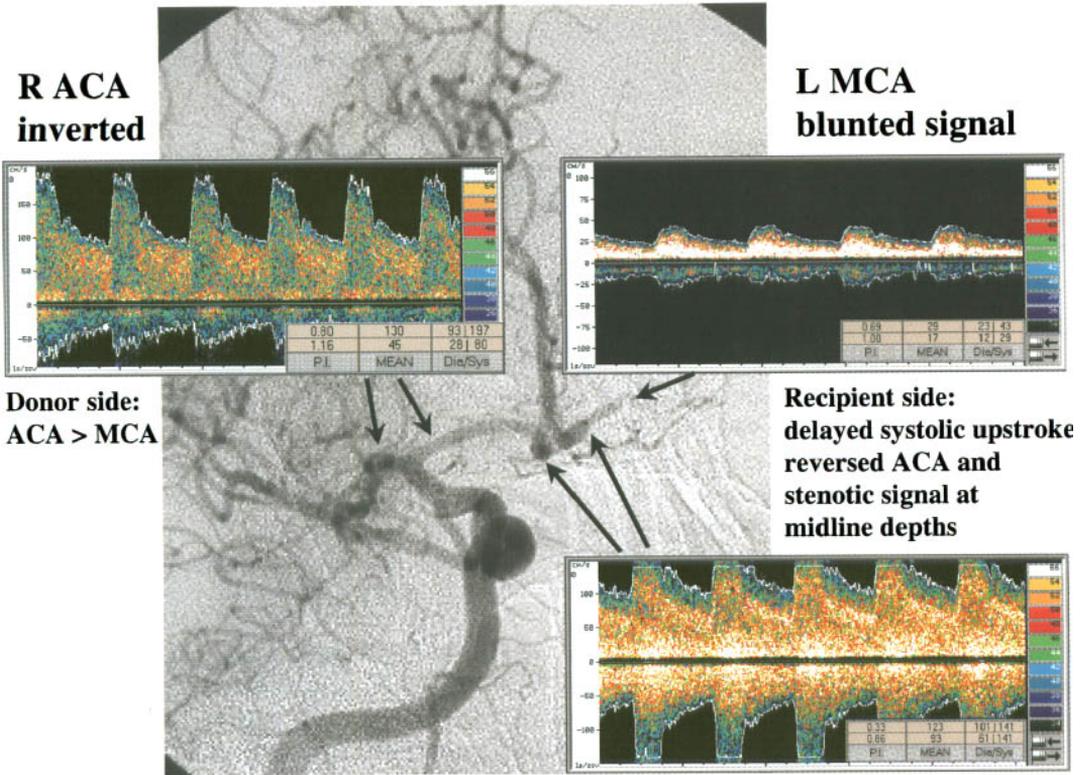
Anterior cross-filling via anterior communicating artery (AComA). Transcranial Doppler shows elevated velocities in the contralateral ACA > MCA (upper left Doppler spectra) of the donor site and elevated velocities at midline depths with reversed unilateral A1
